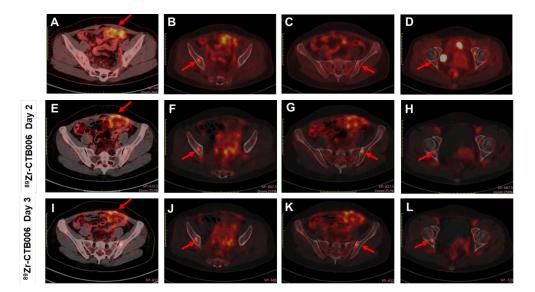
¹⁸F-FDG PET/CT showed high uptake of the thickened peritoneum (A, arrow, SUVmax: 4.9) and the metastasis on the right iliac bone (B, arrow, SUVmax: 3.9), slight uptake of the metastasis on the left iliac bone (C, arrow, SUVmax: 2.1) and the right acetabulum (D, arrow, SUVmax: 2.1). ⁸⁹Zr-CTB006 PET/CT showed inhomogeneous high uptake of the thicked peritoneum (E, arrow, SUVmax: 6.3 at 48h; I, arrow, SUVmax: 4.4 at 72h) and the metastases on the right iliac bone (F, arrow, SUVmax: 4.3 at 48h; J, arrow, SUVmax: 4.4 at 72h), the left iliac bone (G, arrow, SUVmax: 5.3 at 48h; K, arrow, SUVmax: 3.7 at 72h), the right acetabulum (H, arrow, SUVmax: 3.7 at 48h; L, arrow, SUVmax: 4.4 at 72h).
